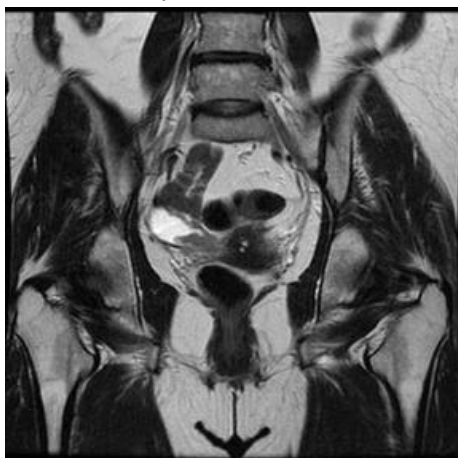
MRI pelvis (coronal view) showing a left adnexal lesion (7.1 × 3.7 × 3.6 cm) with adjacent hydrosalpinx
